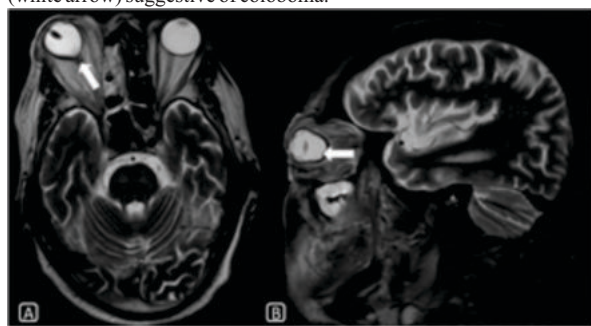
Axial(A) and sagittal(B) T2WI of MRI brain and orbit shows posterior subluxation of right lens with retinal detachment and posterior staphyloma. Left eye appears normal.
